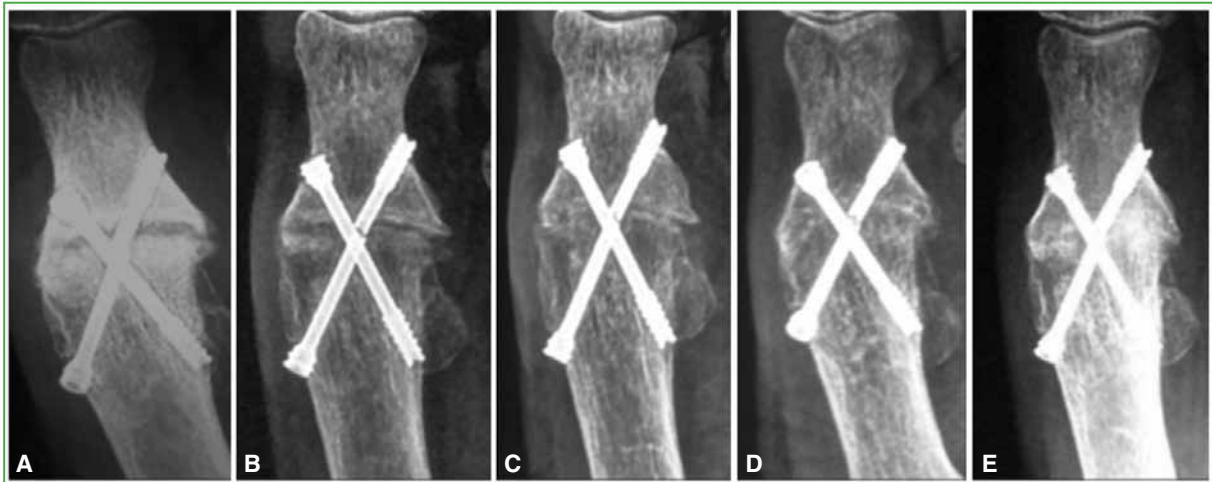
Sequence of plain radiographs of the forefoot with focus on the first metatarsophalangeal joint. A. Failed hallux arthrodesis of 18 months of evolution. B. Two months after three sessions of high-energy focused shockwaves. C. Three months after shock waves. D. Four months after shock waves. The arthrodesis has consolidated and the patient is asymptomatic. E. Radiographic control after 2 years.
